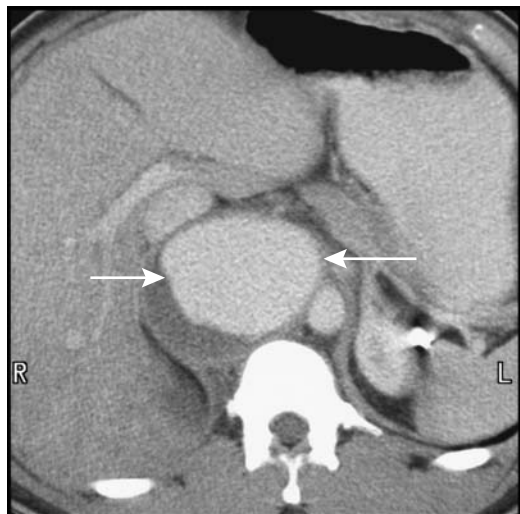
Traumatic pseudoaneurysm secondary to gunshot wound. Computed tomography identifies the aneurysm (arrows) between the aorta and inferior vena cava. (Courtesy of Patrick Fultz, M.D., University of Rochester.)
